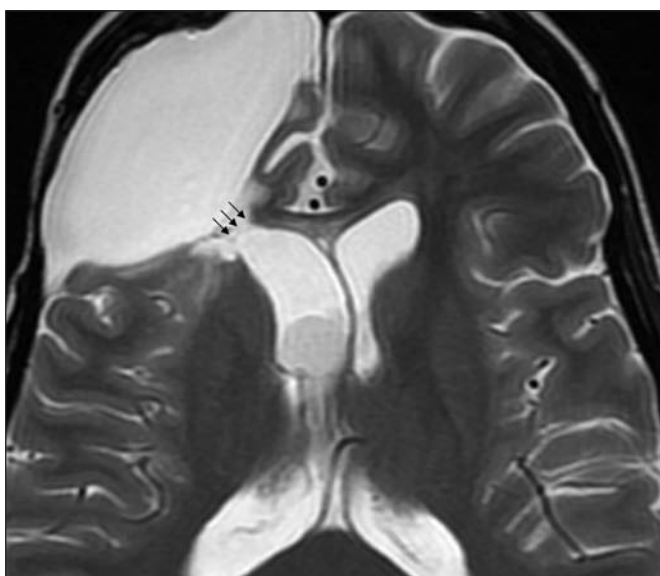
Axial T2-weighted (by 1.5 Tesla GE Sign Excite) demonstrating the ependymal discontinuity (black arrows).
